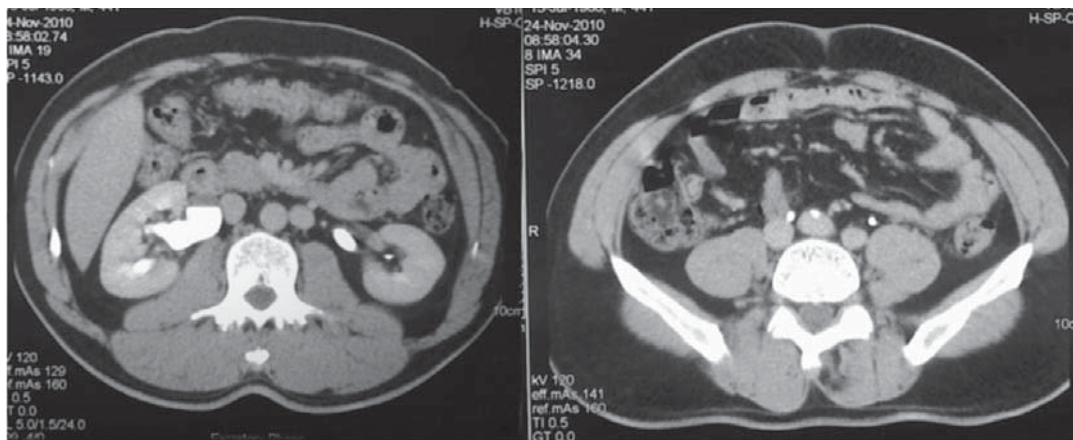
Contrast enhanced CT scans showing bilateral IVC and right ureter lying posteromedially to the IVC.
